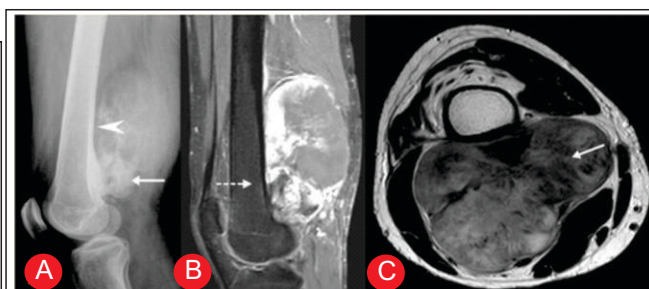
Parosteal osteosarcoma. Lateral (A) radiograph shows ossification (arrow) posterior to the distal femoral metaphysis and a radiolucent cleavage plane from the remaining cortical bone in the proximal aspect (arrow head). (B) Sagittal STIR image shows completely suppressed normal fatty marrow of the distal femur (dotted arrow). (C) Axial T1-weighted image shows a large, cauliflower-like low-signal mass (arrow) arising from the surface of the distal femur. Staging and management of parosteal osteosarcoma is similar to low grade intramedullary osteosarcoma where surgical excision is often curative.
